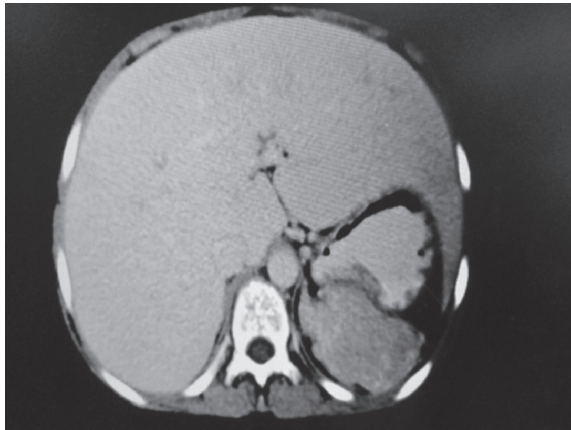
An axial view from the contrast-enhanced CT scan on the portovenous phase shows a slight hyperdense mass, 7 cm in diameter, at left upper quadrant, causing mass effect to gastric fundus.
